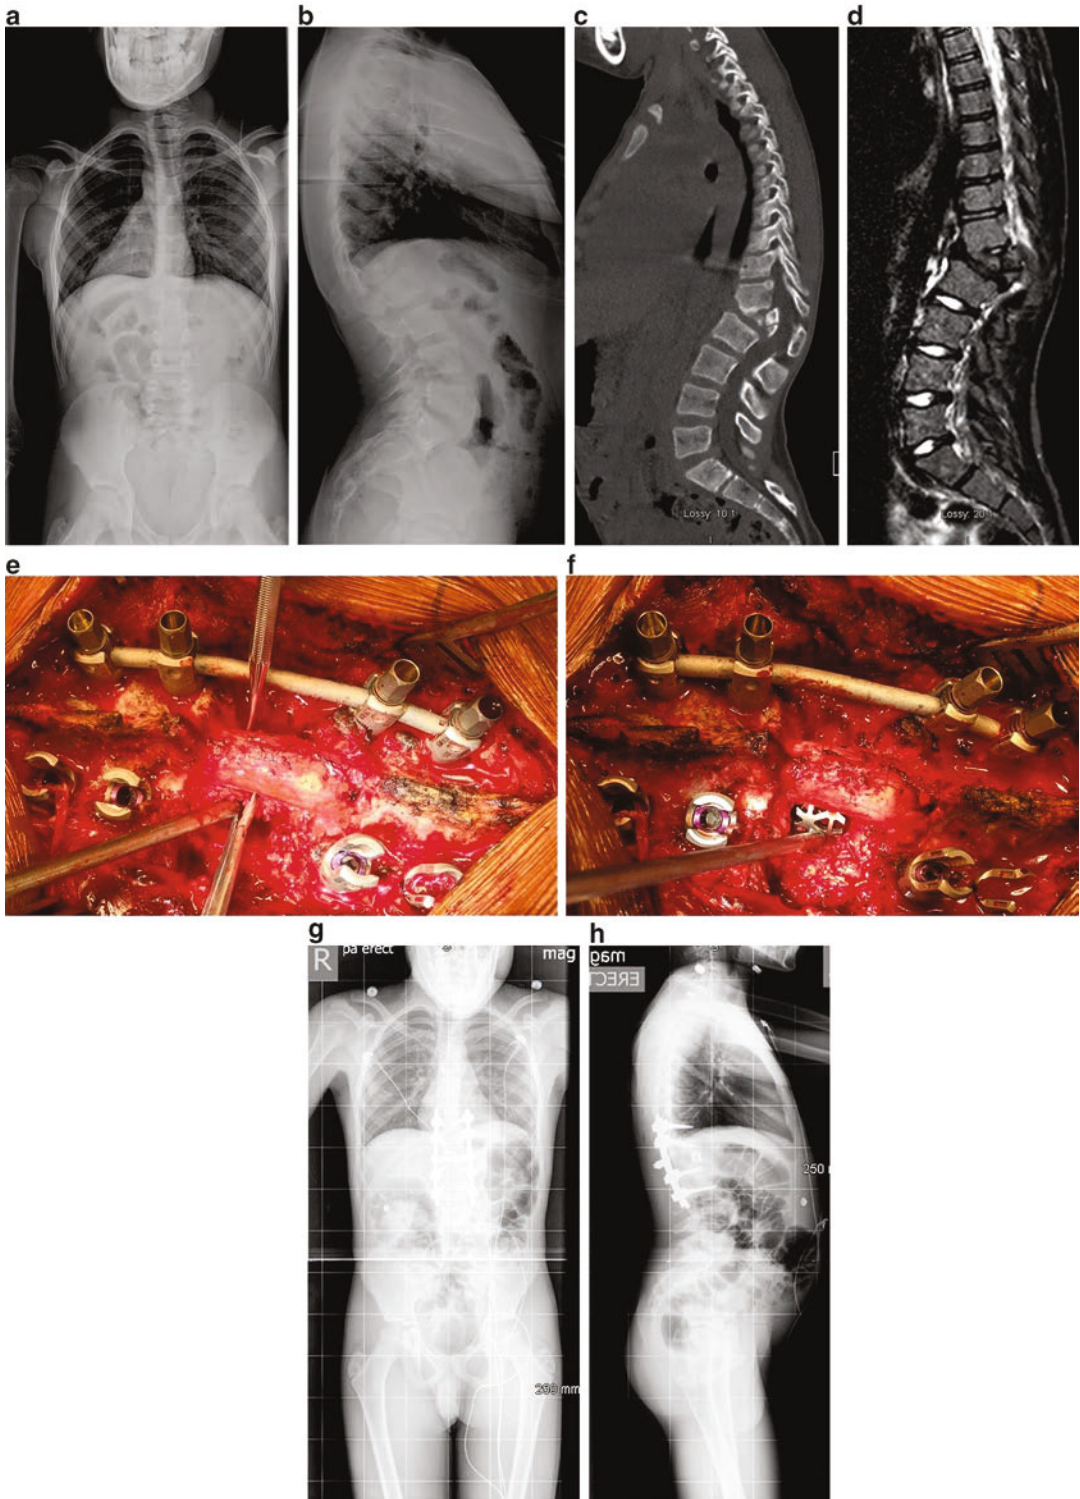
Case example of vertebral column resection. (a) Standing AP 36-inch scoliosis x-ray of patient with congenital kyphosis. (b) Standing lateral 36-inch scoliosis x-ray demonstrates L1 dorsal hemivertebra with mild kyphosis. (c) CT scan sagittal reconstruction demonstrates L1 dorsal hemivertebra with significant encroachment
